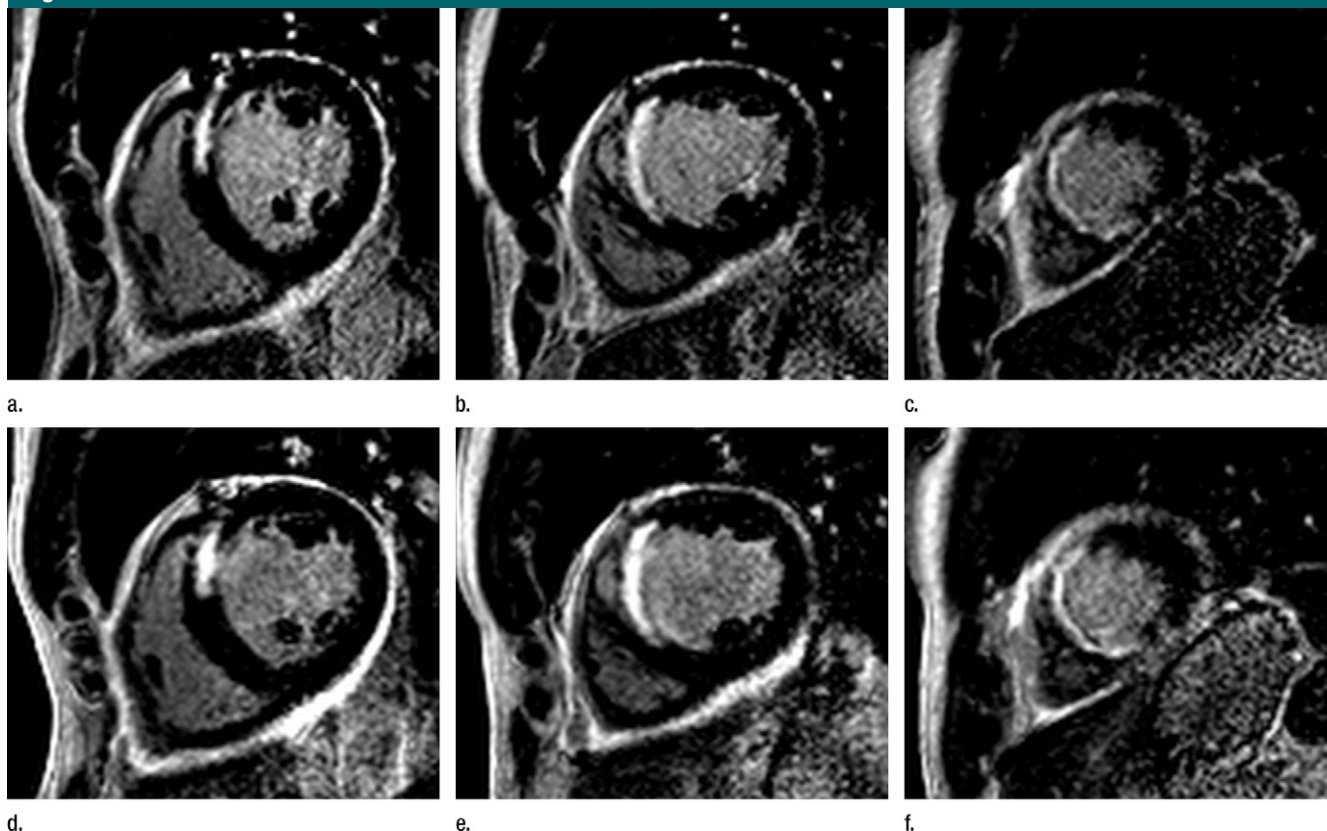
(a–f) Short-axis LGE MR images show excellent image quality for (a) basal, (b) midventricular, and (c) apical sections from 2D acquisitions and (d) basal, (e) midventricular, and (f) apical sections from 3D acquisitions in the same 60-year-old man with subacute myocardial infarction after occlusion of the left anterior descending artery.
